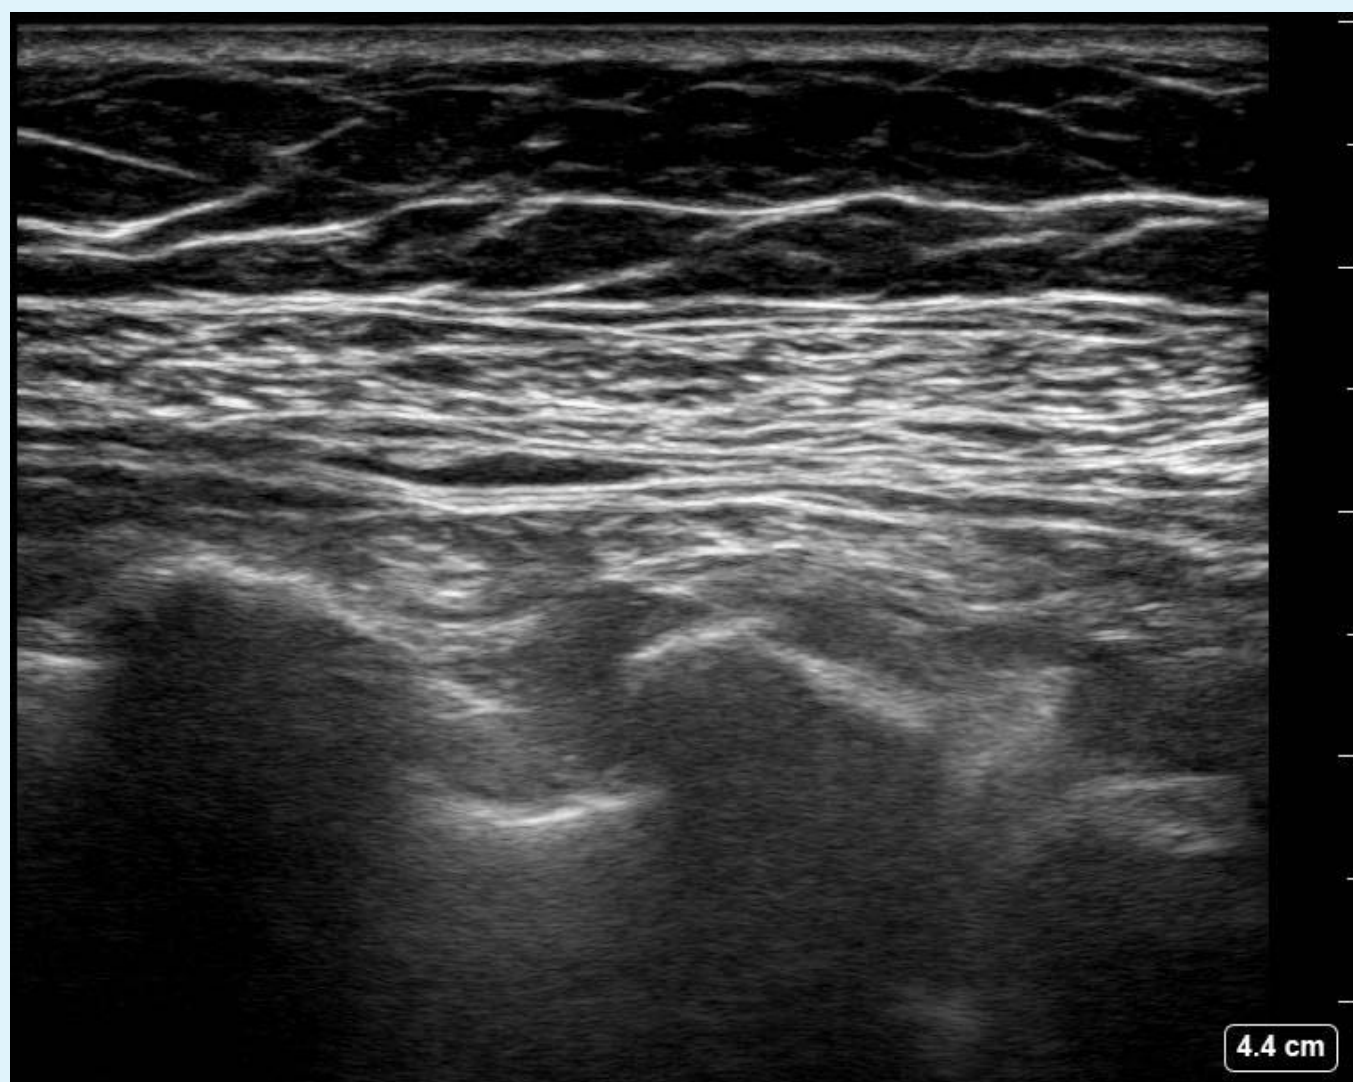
/b/c. Ultrasound imaging showing anatomy prior to PEC block/ Ultrasound imaging showing needle and anesthetic spread/ Ultrasound image showing needle and anesthetic spread with false-color overlay. (Abbreviations: PMj - Pectoralis Major, PMn - Pectoralis Minor, ISM - Intercostal Muscle, Pl. - Pleura)
